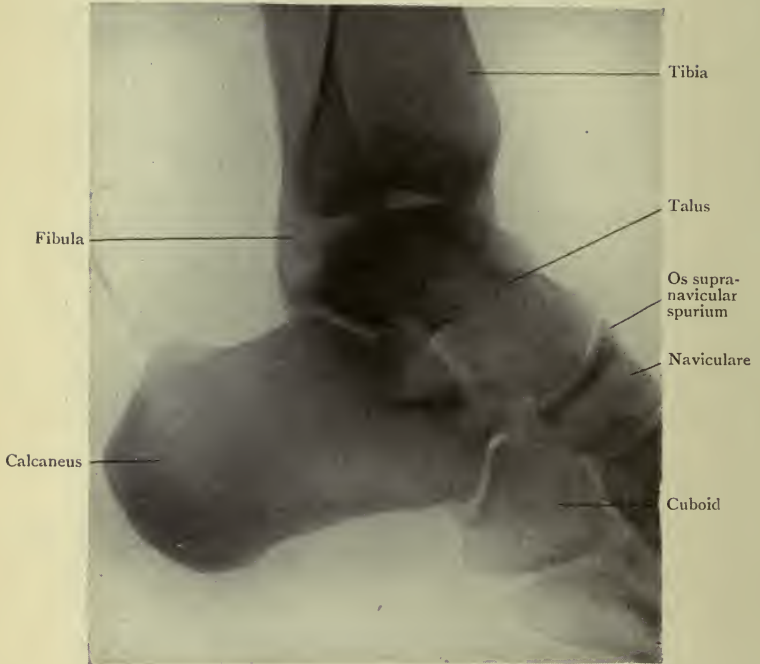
Radiograph of the Foot of an Adult showing an occasional variation.
